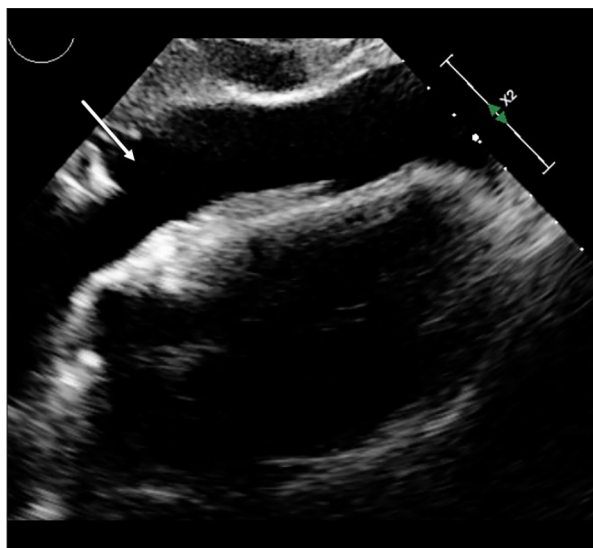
Bedside transthoracic echocardiography demonstrating a large pericardial effusion with right ventricular diastolic collapse, consistent with acute cardiac tamponade. Arrow indicates the effusion compressing the right ventricle.
